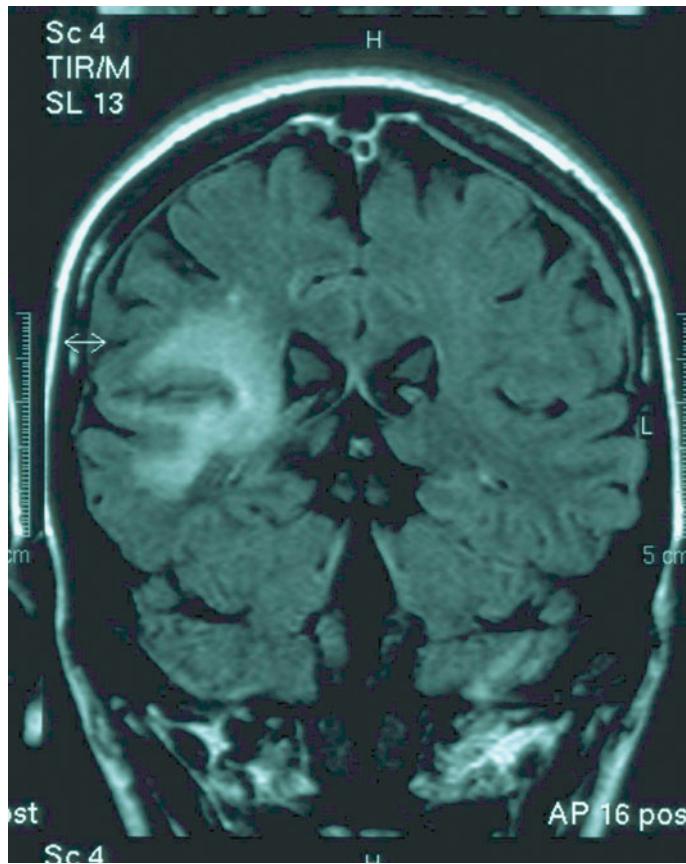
MRI brain scan showing lesions of PML which resulted in a homonymous hemianopia.
